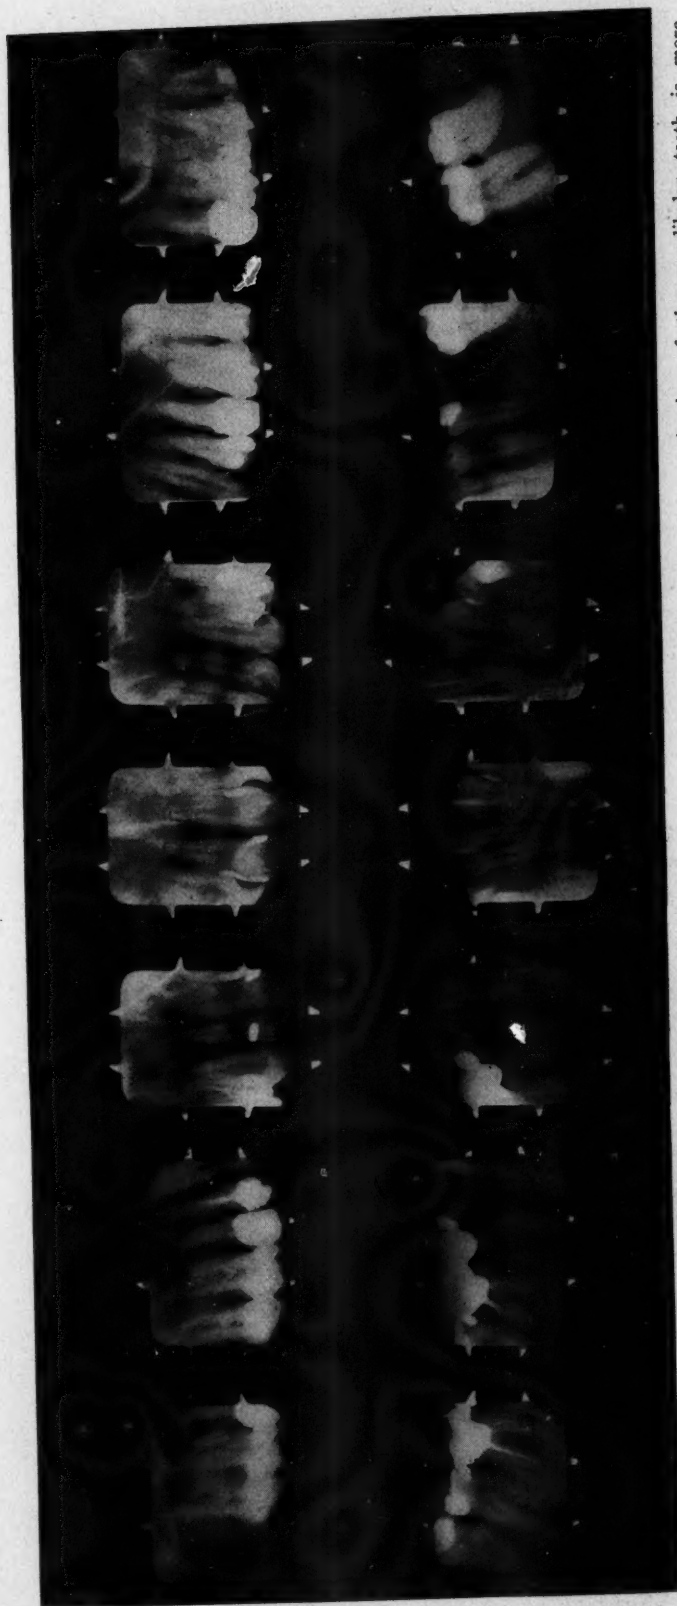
A 14-negative examination has distinct advantage over a 12-negative examination in that the examination of the mandibular teeth is more thorough. When only 5 films are used for the mandibular teeth, the radiographic view of the mandibular anterior teeth is not always as good as it should be and sometimes one fails to get a good view of all of the molars.
